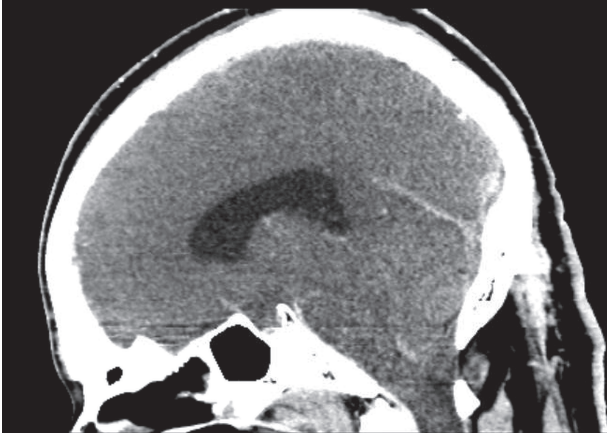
CT head (contrast). Axial Image: there is lateral ventricular dilatation, asymmetric to the right with evidence of debris in the occipital horn of the right lateral ventricle.
